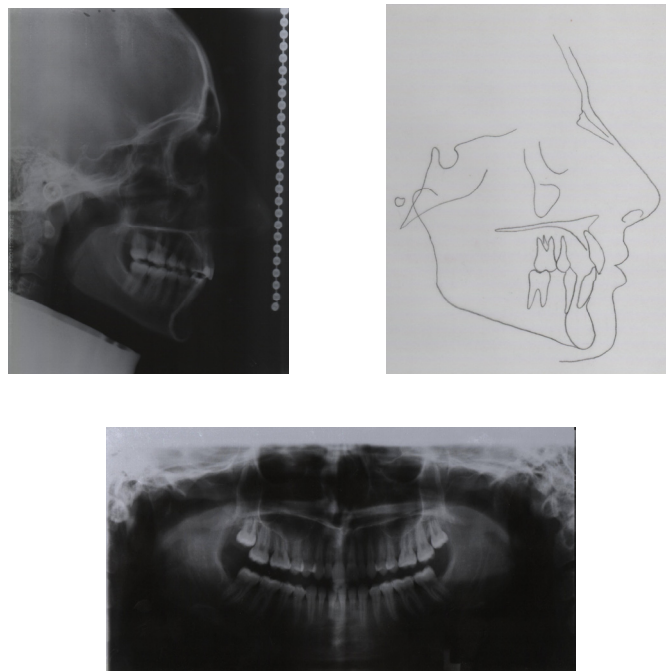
Figs 8-a to 8-c, pretreatment cephalogram, cephalometric tracing and panoramic radiograph.
